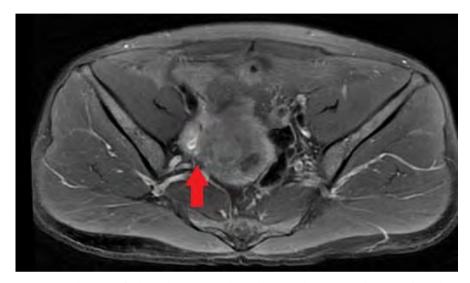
Pelvic MRI findings (T2W2): In the right appendix area, is a lesion with unclear local uterine boundary, and slightly high signal intensity.
